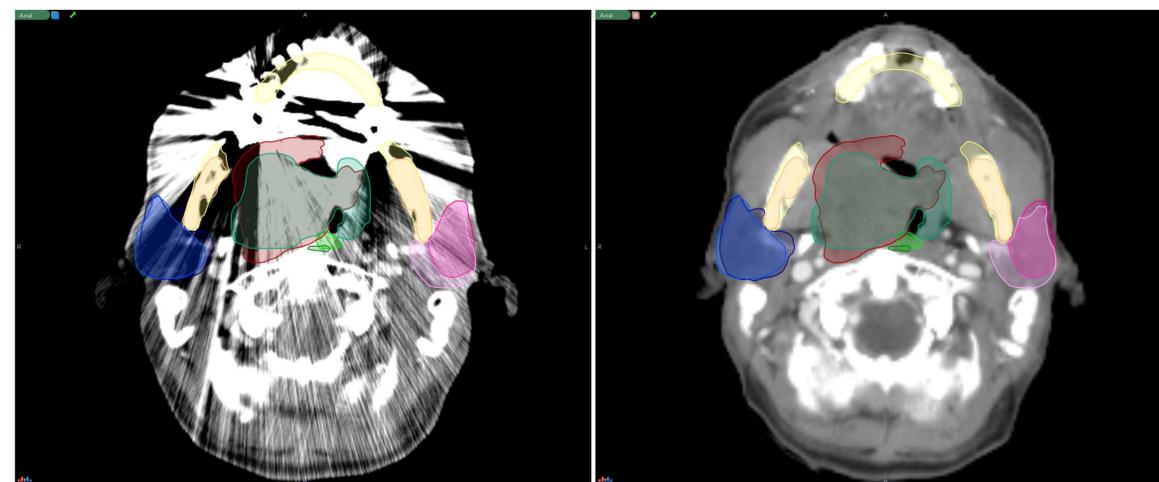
Artifact-induced observer variability; contours from pre-dental-extraction (Left) overlaid onto the post-dental-extraction (right) CT scan
